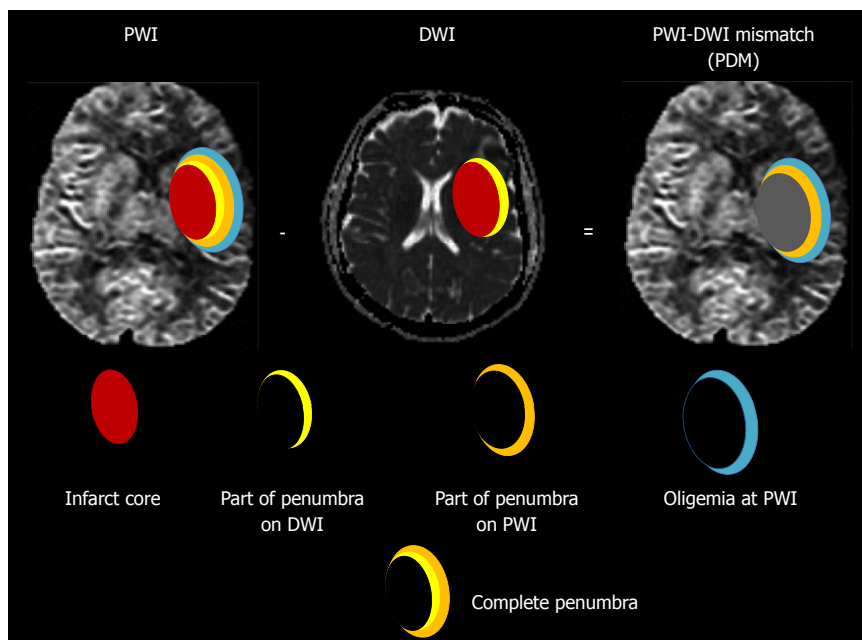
Modern concept of ischemic penumbra. Early abnormality on diffusion weighted imaging (DWI) equals the infarct core plus a part of the tissue at risk (penumbra); and the perfusion deficiency on perfusion weighted imaging (PWI) includes the infarct core plus penumbra and region of benign oligemia. PWI-DWI mismatch (PDM) does not optimally define the ischemic penumbra.
